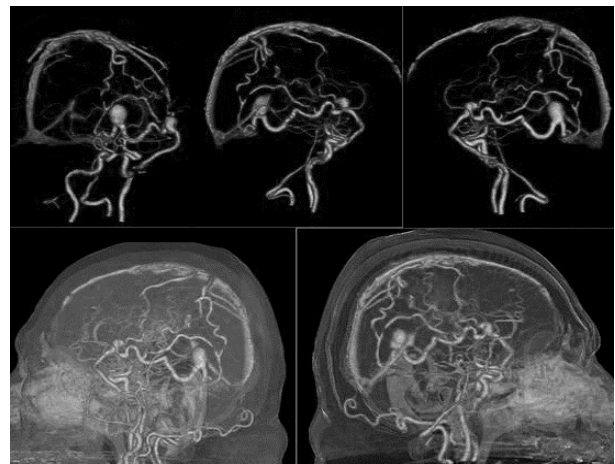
CT angiography 3D reconstruction study showed Tentorial DAVF, the fistulous connection was between the middle meningeal artery, tentorial branches of the meningohypophyseal trunk of the Internal Carotid Artery with the transvers-sigmoid sinuses junction and the straight sinus, with venous varices that render the lesion as a high risk for haemorrhage DAVFs.
